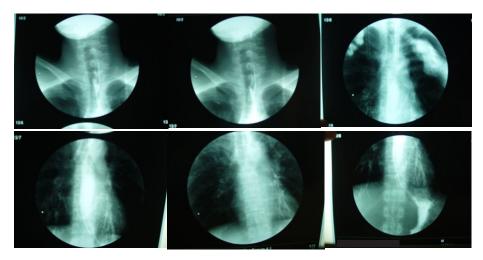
The barium-swallow X-rays with contrast showed normal oesophageal motility
